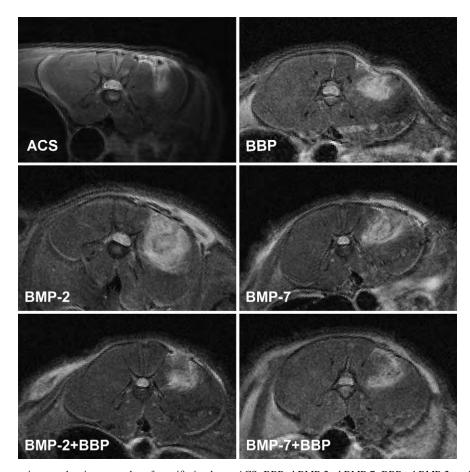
Magnetic resonance images showing examples of specific implants: ACS, BBP, rhBMP-2, rhBMP-7, BBP+rhBMP-2, and BBP+rhBMP-7. ACS, absorbable collagen sponge; BBP, bone morphogenetic protein-binding peptide; rhBMP, recombinant human bone morphogenetic protein.
